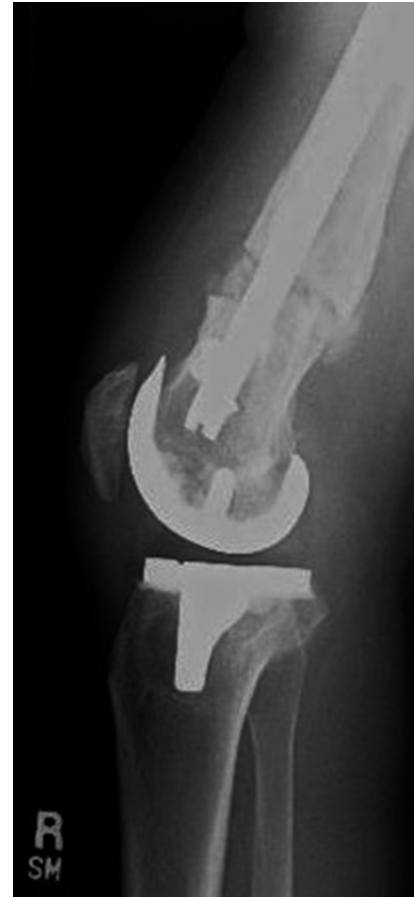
Lateral knee radiograph taken at 6 weeks postoperatively.
